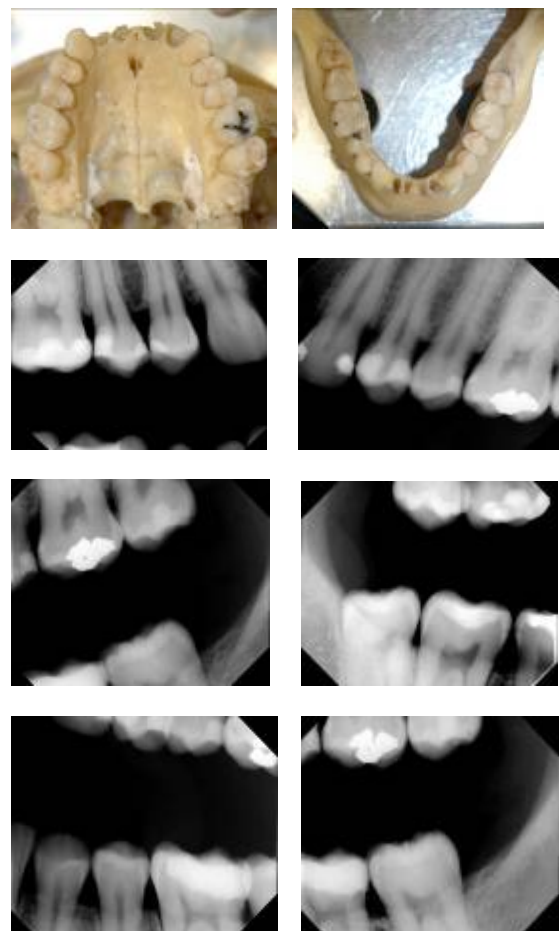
CASE 3. The PM photographs and radiographs of the unknown remains.
